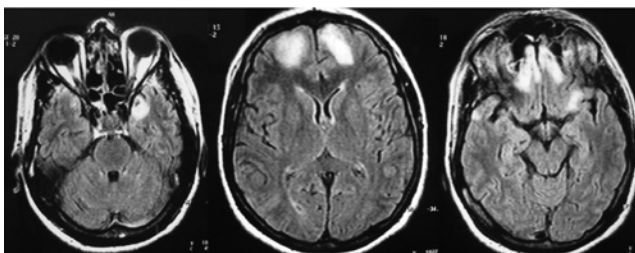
A 36-year old HIV-infected man presented in May 2010 with anxious disorders, psychomotor agitation, discrete memory impairment, and visual hallucination started 2 weeks before admission. A brain CT performed in the emergency sector of a peripheral hospital was normal. He was discharged of this hospital with 2 mg daily of risperidone and with a psychiatric consultation scheduled within 6 weeks. In the end of June 2010, he was admitted at FIOCRUZ after a generalized seizure. He had a severe memory impairment, but no focal neurologic deficit was present. CD4 counts were 108 cells/mm³. A brain MRI (FLAIR sequence) disclosed a hyperintense signal in right temporal lobe and orbitofrontal regions, bilaterally. A lumbar puncture was performed, showing a discrete lymphocytic pleocytosis and protein elevation. IV acyclovir was started immediately. PCR HSV-1 was positive and the therapy was maintained for 21 days. A new PCR test was done before patient's discharge and was negative. He was left with a mild memory deficit only.
